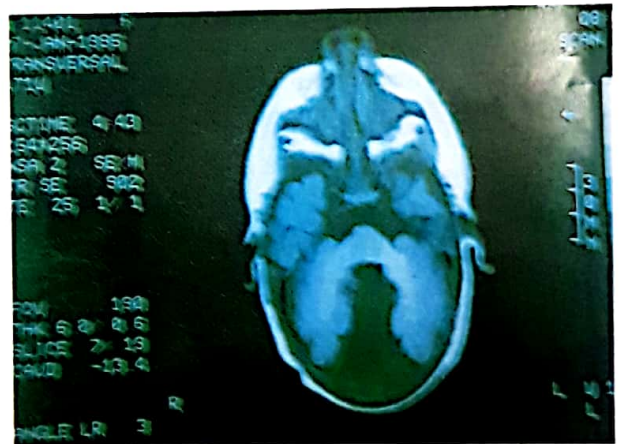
Magnetic resonance images show enlarged fourth ventricle with absence of hydrocephalus.
